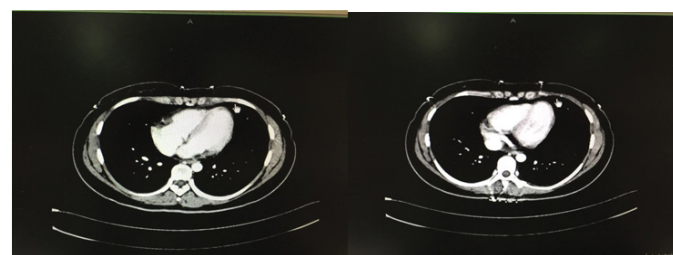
No pleural effusion in the abdominal enhancement CT scan on the first day acute attack.
